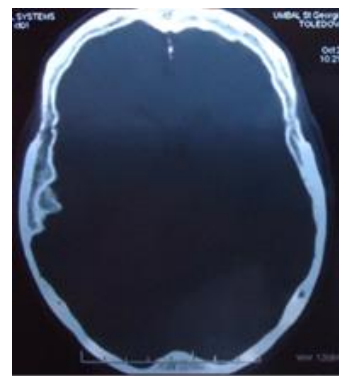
CT - bone lesion caused by meningioma
